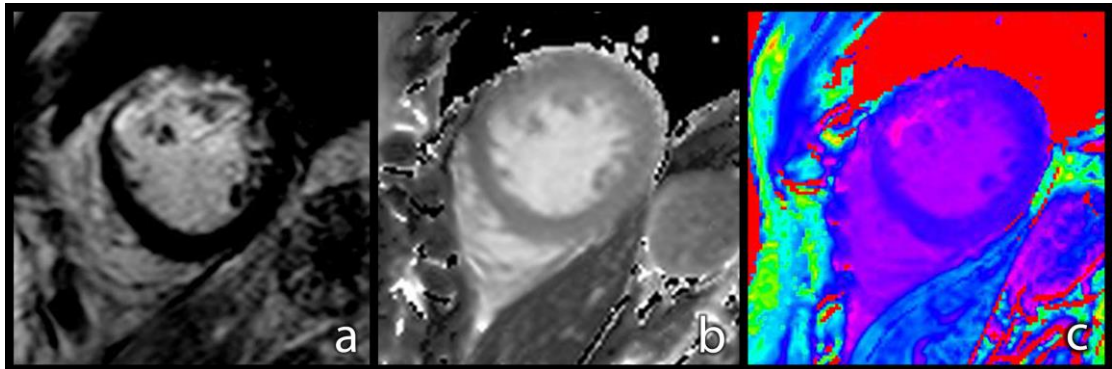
Weighted and parametric T1 acquisition in acute myocardial infarction. Identical patient and slice position shown for comparison. T1-weighted LGE imaging (Panel a), pre-contrast parametric T1 map (Panel b) and an ECV map (Panel c), generated from pre-and post-contrast T1 parametric acquisitions are shown.
